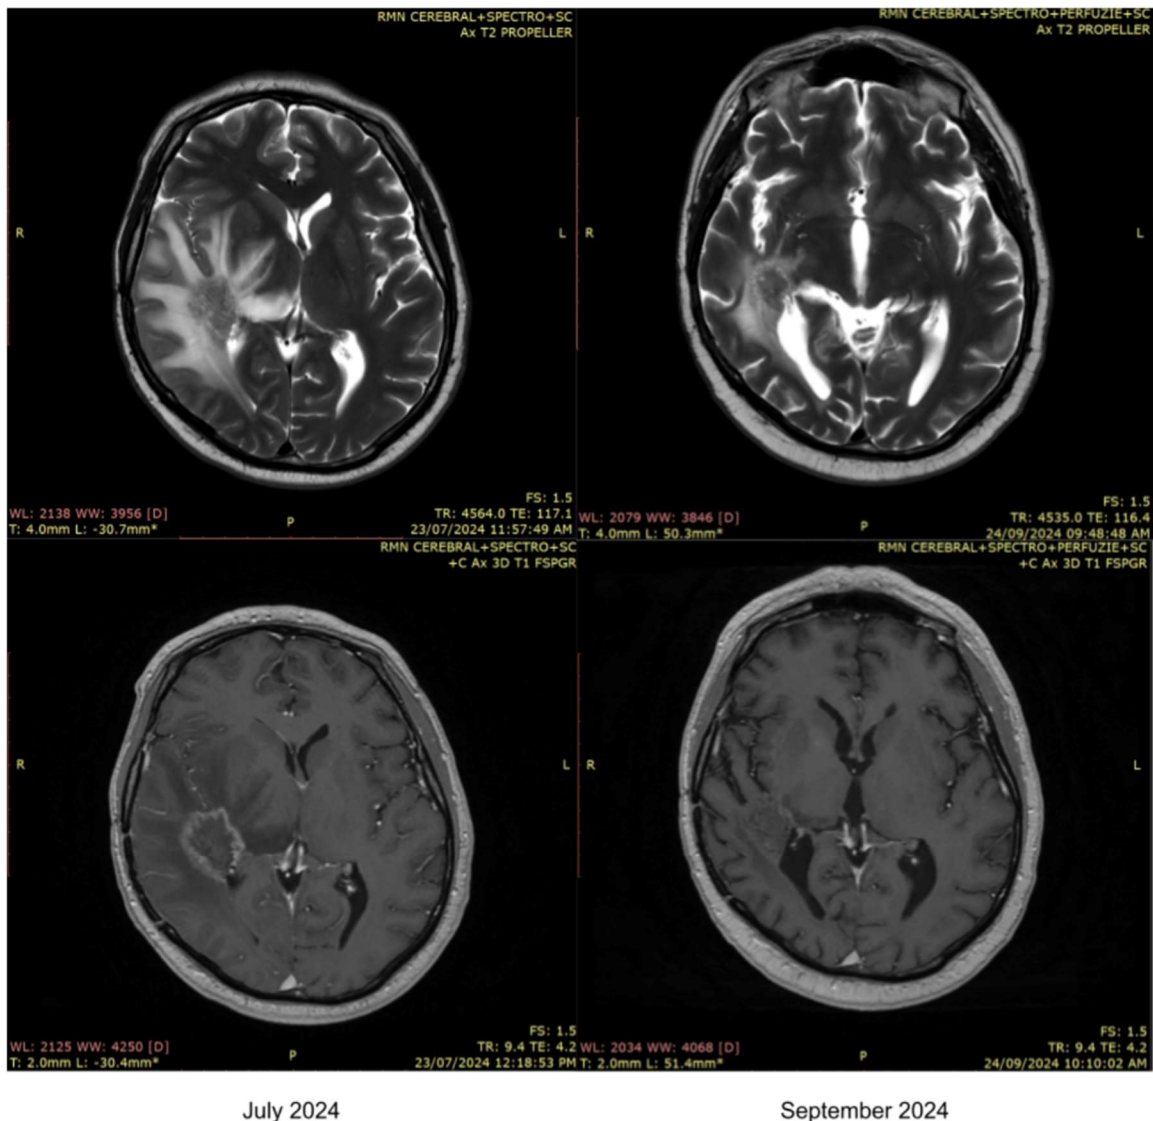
Comparative MRI images showing improvement of radiation necrosis.
